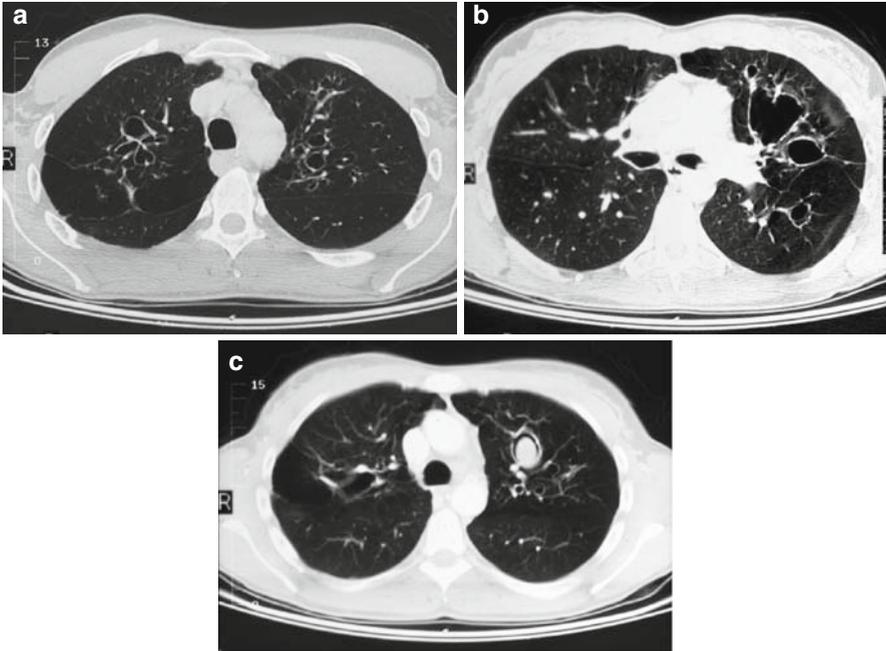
(a) Chest computed tomography (CT) scan in a patient with allergic bronchopulmonary aspergillosis showing bilateral central bronchiectatic changes. Few years later, the chest CT showed cavitory areas in the *left upper lobe* (b). An aspergilloma developed at the site of the large cavity in the *left upper lobe* (c) (Courtesy of Dana Kissner, MD)
